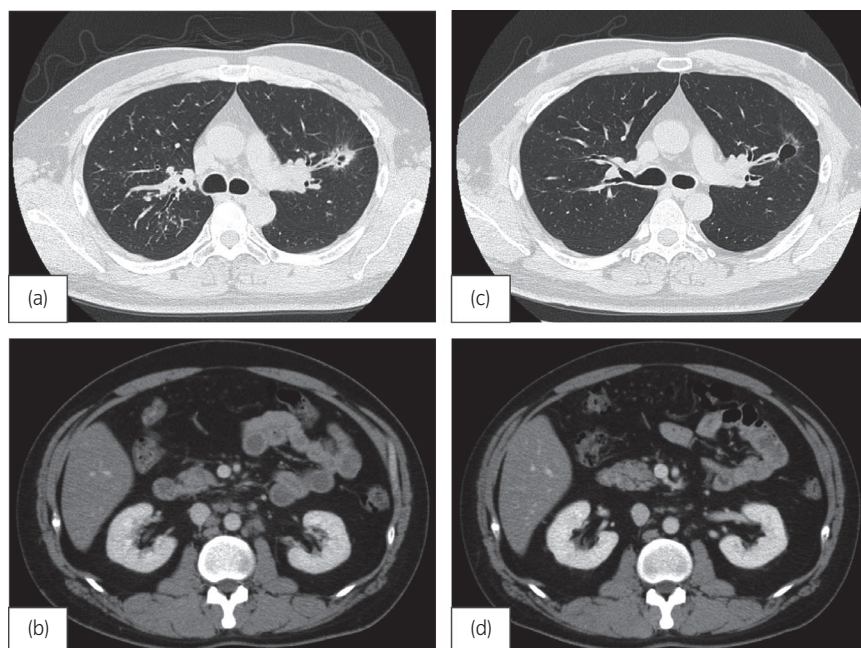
CT scans of the chest and abdomen. A nodular lesion with an internal cavity in the left upper lobe of the lung (a), hilar lymph nodes, and para-aortic lymph node swelling (b) before corticosteroid therapy. A significant decrease in the size of the lung nodule (c), hilar lymph nodes, and para-aortic lymph nodes (d) after treatment.
